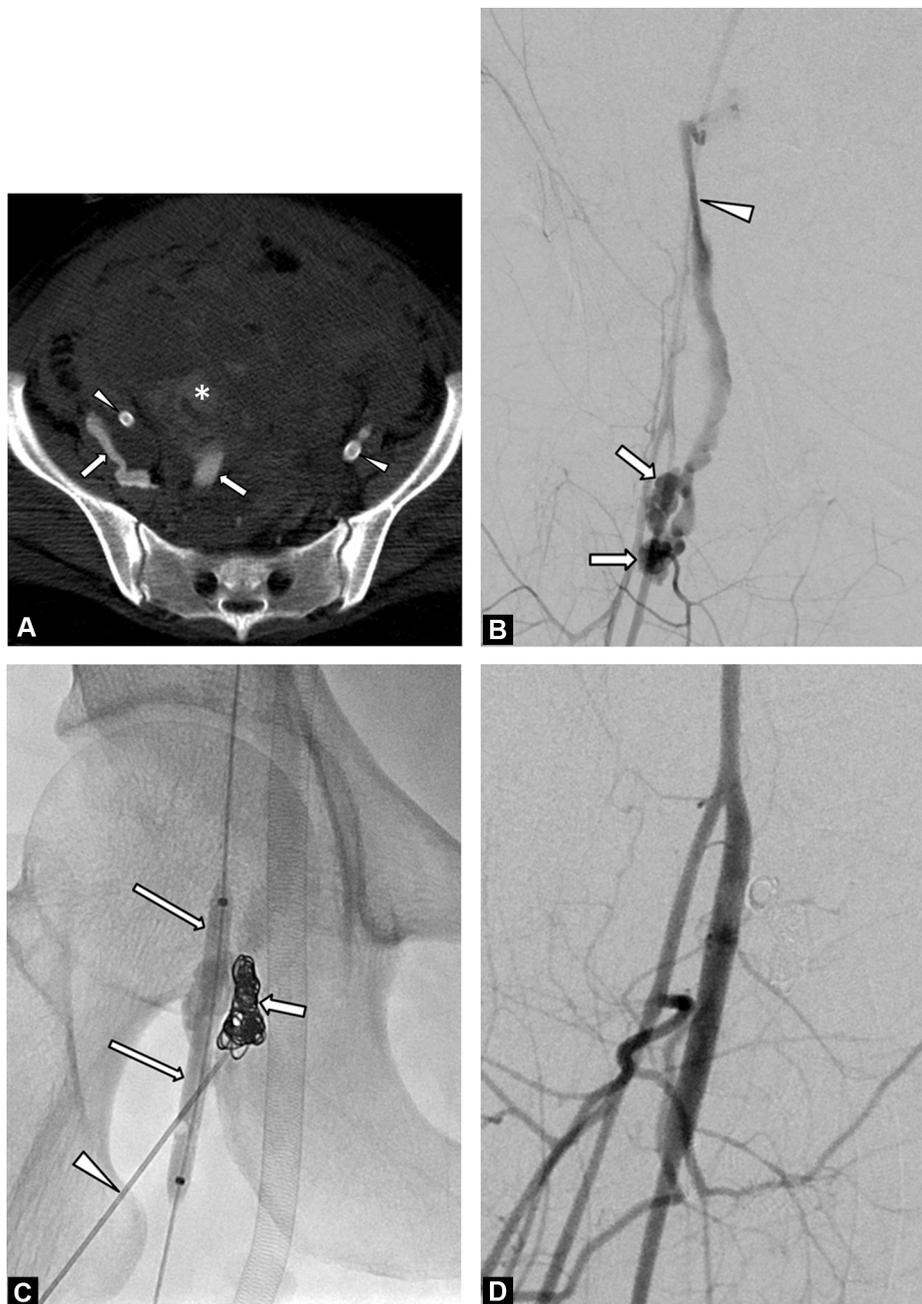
A 31-year-old woman with superficial femoral artery (SFA) rupture secondary to PECMO (Patient No. 1). A. A post-contrast CT scan before interventional treatment showing contrast extravasation (arrows) from the right SFA and a hematoma (asterisk) in the pelvic cavity. Bilateral cannulated femoral veins (arrowheads) are notable. B. Common femoral artery angiogram through the left brachial artery access showing active bleeding with pseudoaneurysm (arrows) from the right SFA. Active bleeding reflux into the pelvic cavity is evident (arrowhead). C. The pseudoaneurysm outflow was embolized with microcoils (arrow) and 4000 IU of thrombin was then injected into the pseudoaneurysm through the Chiba needle (arrowhead) with inflated balloon catheter assistance (long arrows). D. Post-thrombin injection angiogram showing no further bleeding into the pseudoaneurysm, and smooth blood flow through the SFA.
